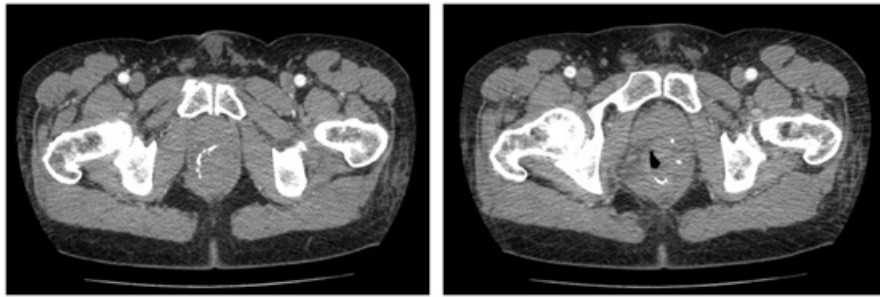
CT scan shows the absence of free air in the mesorectal and pelvic area and the integrity of the suture.
